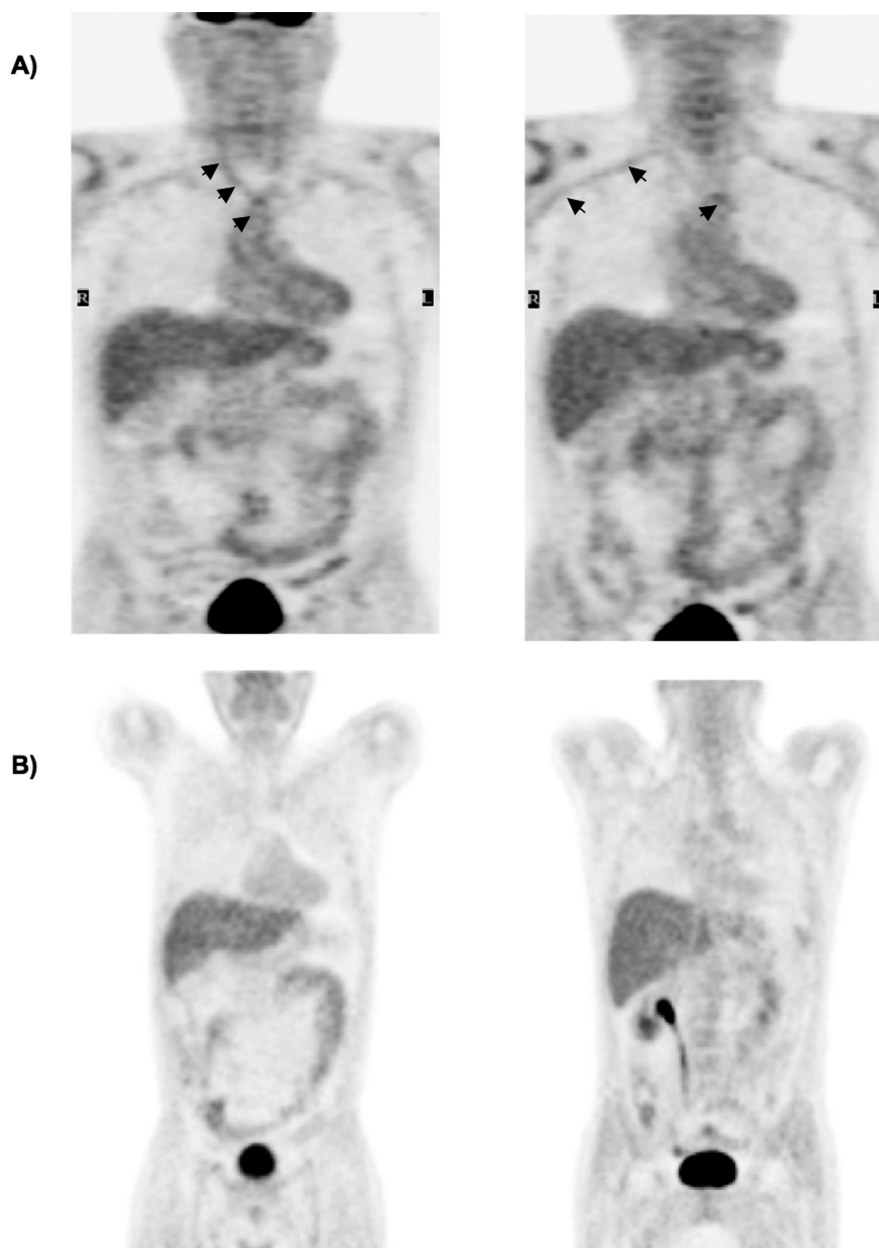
A) PET scan of a patient with GCA (case 14 from Table I) showing an increased FDG uptake in the ascending aorta, aortic arch, descending aorta, carotid, subclavian, axillary and brachial arteries suggestive of active vasculitis. B) The same patient 4 months after the onset of treatment with tocilizumab. Marked reduction of mural diffuse uptake of large vessels and their main branches was seen (Courtesy of Dr. Narváez, Department of Radiology, Hospital Universitari de Bellvitge).
